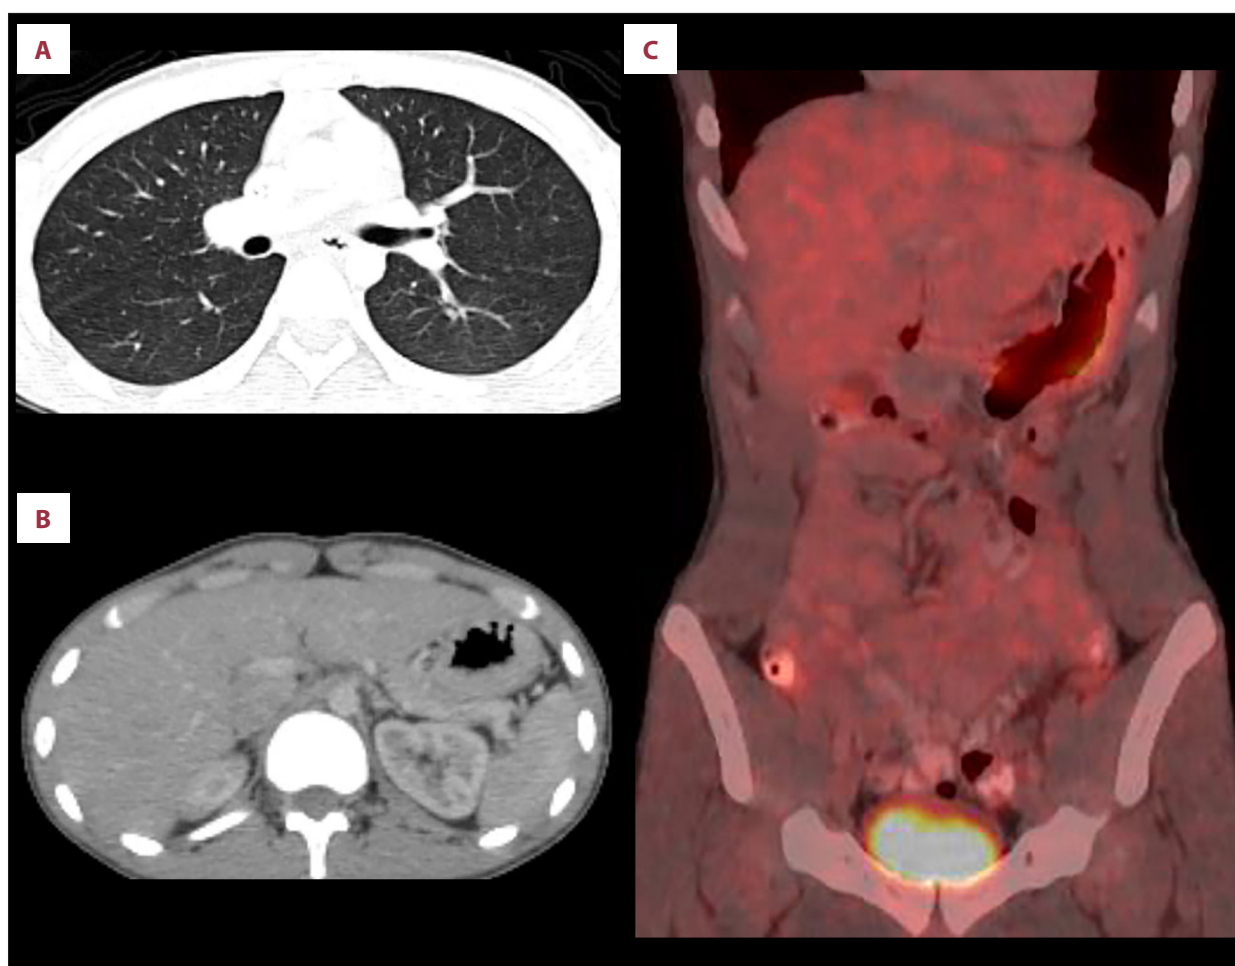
Follow-up computed tomography (CT) during surveillance. (A-C) CT examination demonstrating continued absence of local recurrence or distant metastases. Bilateral pulmonary nodules remained stable in size and appearance, consistent with benign lesions.
